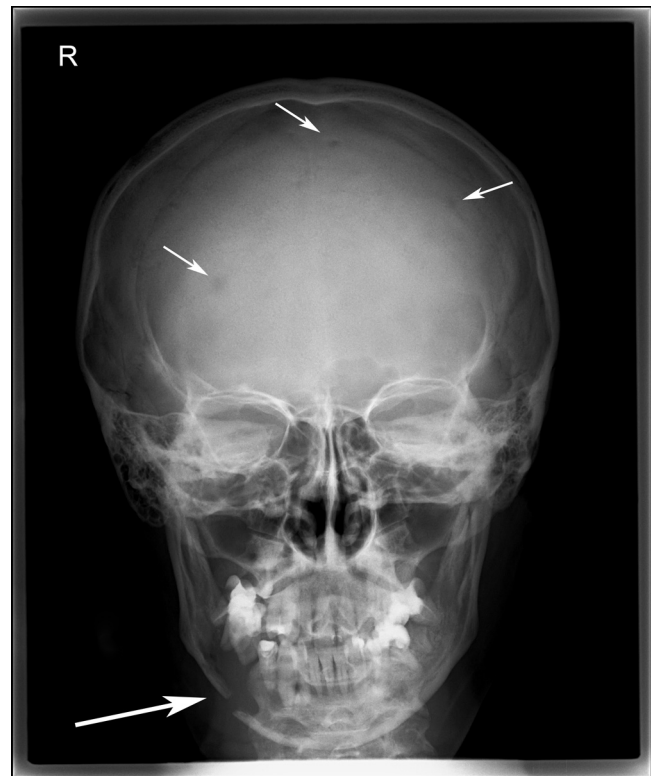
Skull X-ray. Osteolytic lesions seen in the bones of the skull. The longer arrow shows the pathological fracture of the right mandible, the shorter arrows show osteolytic lesions in skull)
